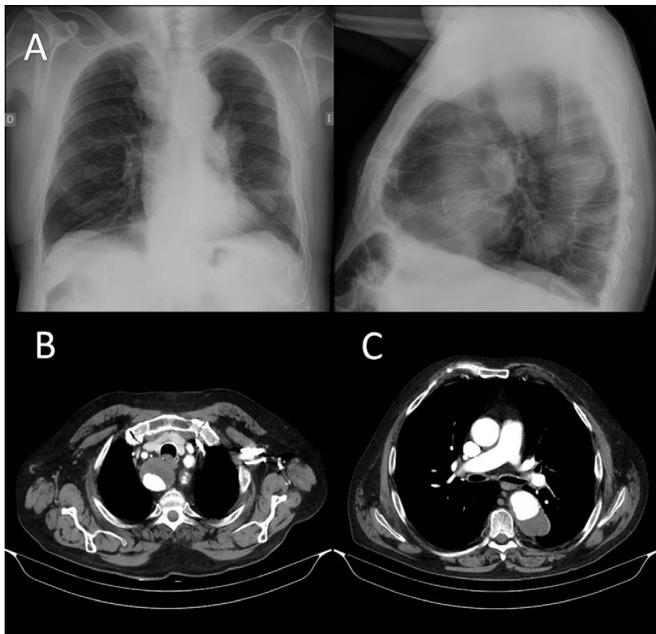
(A) PA and lateral chest X-ray showing mediastinal widening with images significant for masses. (B) Chest CT with intravenous contrast, showing an aberrant right subclavian artery that originates in the aortic arch distal to the left subclavian artery, running behind the esophagus towards the right side, with a large, partially thrombosed aneurysm. (C) Partially thrombosed aneurysm of the descending aorta.
